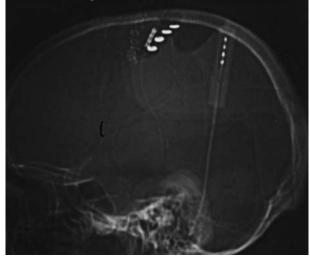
Radiograph showing a motor cortex stimulator in place. A posterior craniectomy is seen where a parietal cortical stimulator had previously provided a similar degree of analgesia
